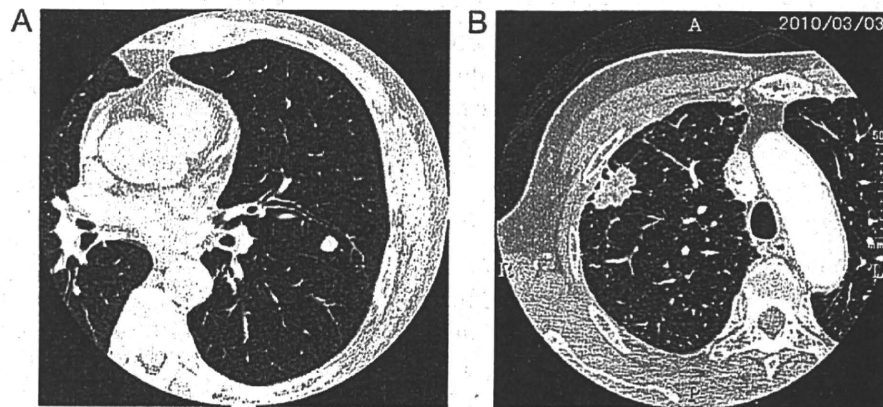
High-resolution CT image of a solid nodule. (A) Granuloma and (B) squamous cell carcinoma.
